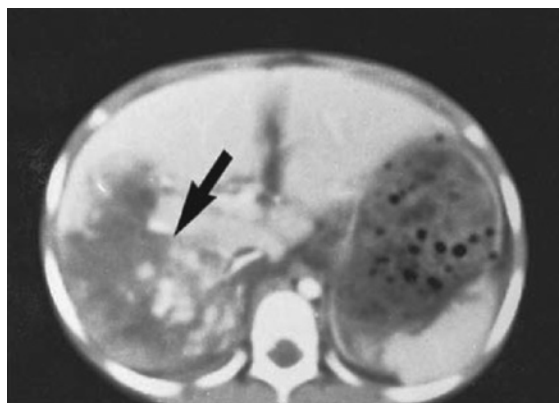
CT scan of the upper abdomen showing a ruptured liver (arrow).
